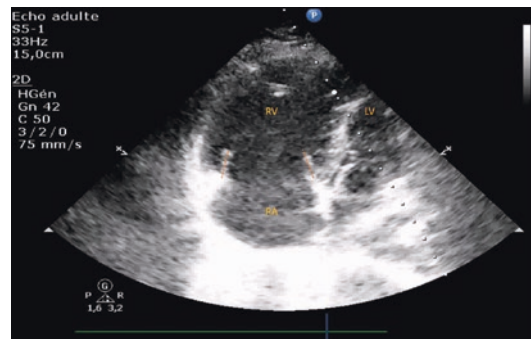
Right ventricle dilatation during pulmonary embolus in apical four-chamber view
